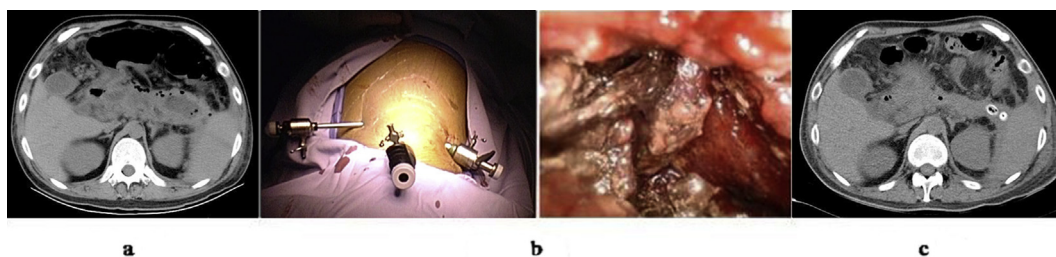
VAD (retroperitoneoscopy) in a 28-year-old male with a disease duration of four weeks. a. CT scan showing secondary infection of WON at the tail of pancreatic body, where a safe PCD approach could not be confirmed. b. Retroperitoneoscopy showing location of trocar (right lateral position) and pancreatic necrosis. c. CT scan showing substantial improvement 48 days after retroperitoneoscopy. PCD, percutaneous catheter drainage; VAD, video assisted debridement; WON, walled-off necrosis.
